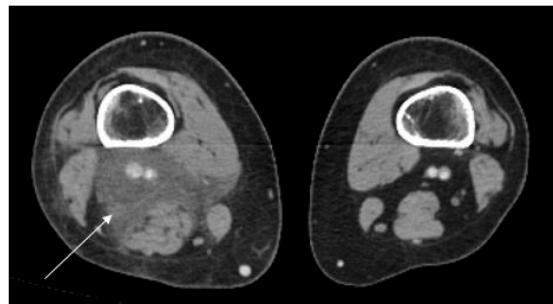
CT scan showing inflammation of the proximal portion of the right lower limb, where a subcutaneous node was palpable (arrow).
